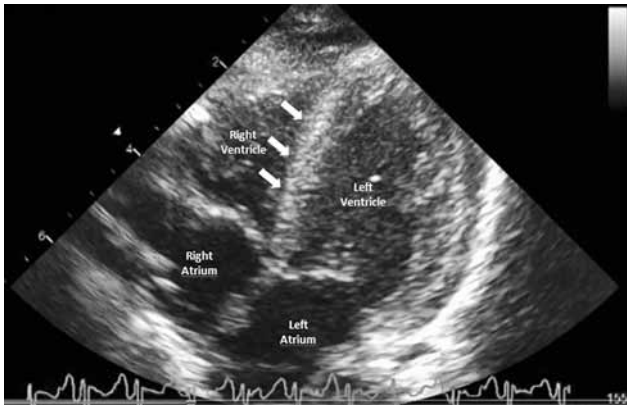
A two-dimensional echocardiographic image showing left ventricle following surgery.
